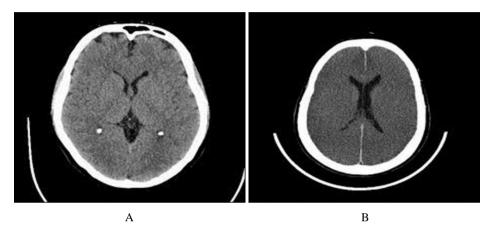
(A): Normal CT brain at admission. (B) CT brain with diffuse cerebral edema on day 2 of admission with effacement of cortical sulci and gyri in both cerebral hemispheres
